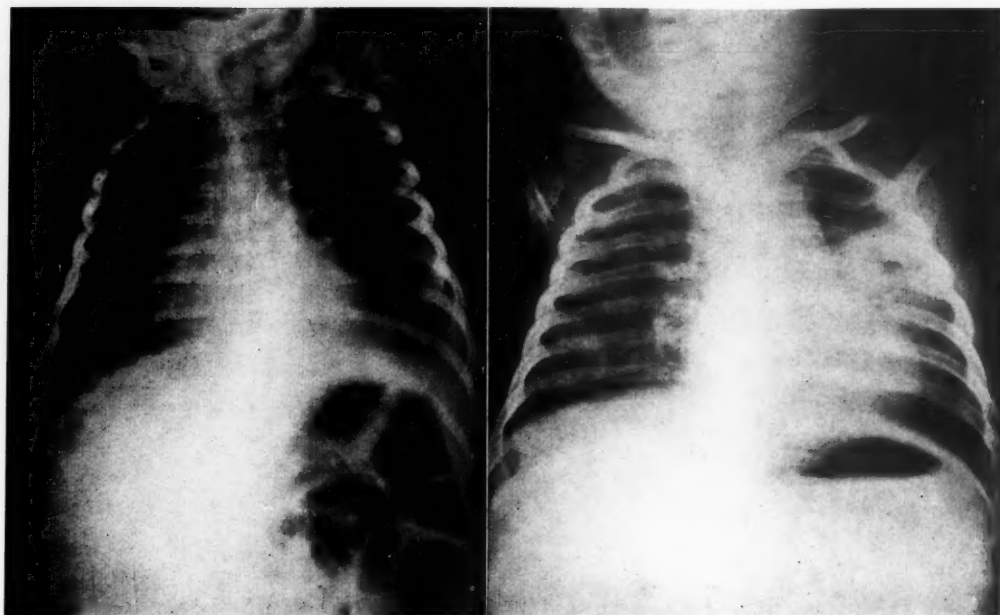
X-ray film was reported "normal", later considered to show emphysema. Note distended bowel. This baby died two days later from extensive bilateral suppurative pneumonia, and had paralytic ileus. FIGURE II.—Consolidation of upper lobe of left lung, with localized area in lower lobe of right lung.
